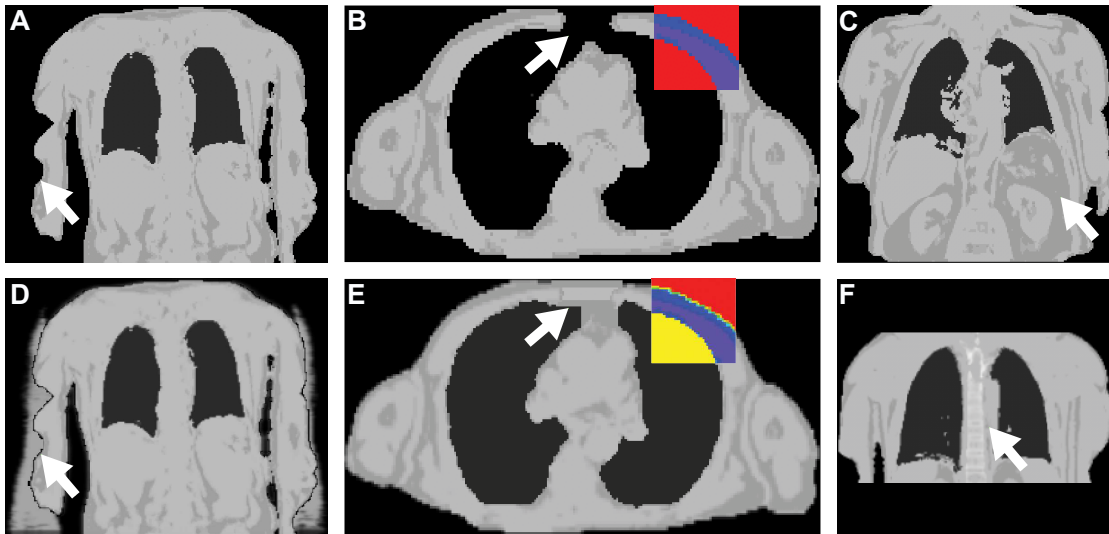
Examples of artifacts and corrections in the MRI-based attenuation correction maps. A. Truncation artifact, where the arms of the patient are outside the MR field-of-view. B. Susceptibility artifact caused by surgical sternal wires. Note the failed lung segmentation, where lung attenuation values have been incorrectly assigned to background (red color in the box insert). C. Tissue inversion artifact with a soft-fat tissue swap. D. Correction of truncated arms using the background tracer activity [80]. E. Susceptibility artifact correction using a post-processing algorithm [12]. Note that the lungs have been "filled" with lung attenuation values (yellow color in the box insert). F. Correction of missing bone by adding an atlas-based bone model of the spine [82].
